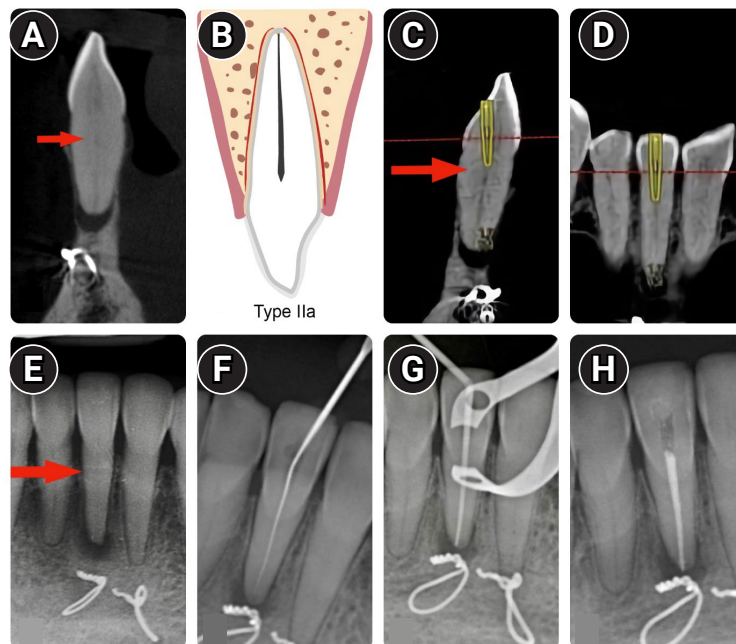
Characteristics of Type IIa root canal classification. (A) Tomographic image. The red arrow indicates the start of the canal lumen (target point). (B) Type IIa classification scheme. (C) Planning access to the pulp chamber/root canal in a sagittal slice. The red arrow indicates the target point for planning (start of the canal lumen). (D) Planning for pulp chamber/root canal access coronal slice. (E) Initial radiograph. The red arrow indicates the start of the root canal. (F) Initial root canal negotiation with a file to determine the temporary working length. (G) Gutta-percha master point fitting before root canal filling. (H) Filled canal.
